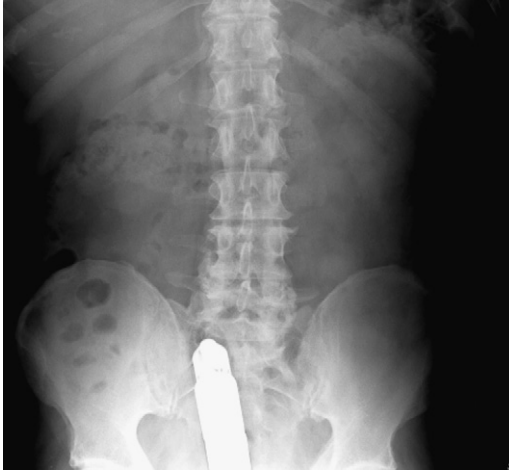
Rectal dildo on abdominal plain film. (Courtesy of Joel Goldberg, MD, Boston, MA.)
